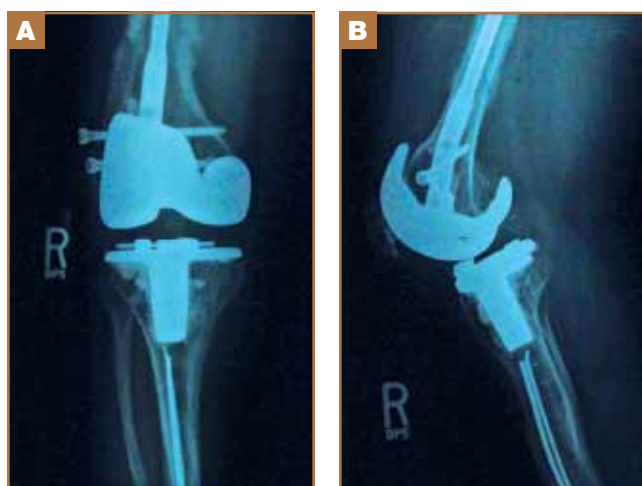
AP (A) and lateral (B) radiographs of right knee status post TKA and femoral and tibial osteotomies.
